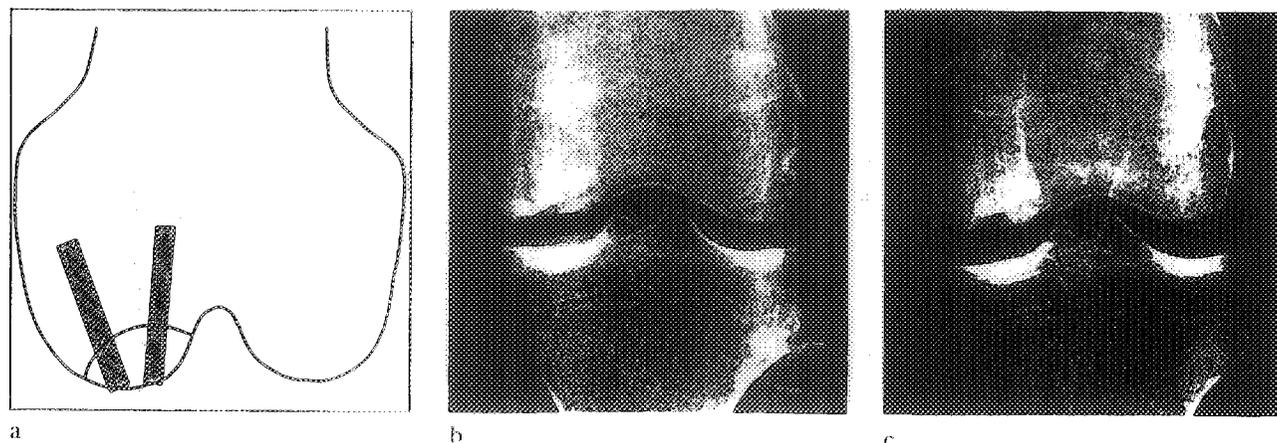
Fixation of osteochondral fragment in osteochondritis dissecans of the knee (a). Radiograph of the knee seen preoperatively (b) and one year after fixation with two 2 by 30 mm BIOFIX®-rods (c).
